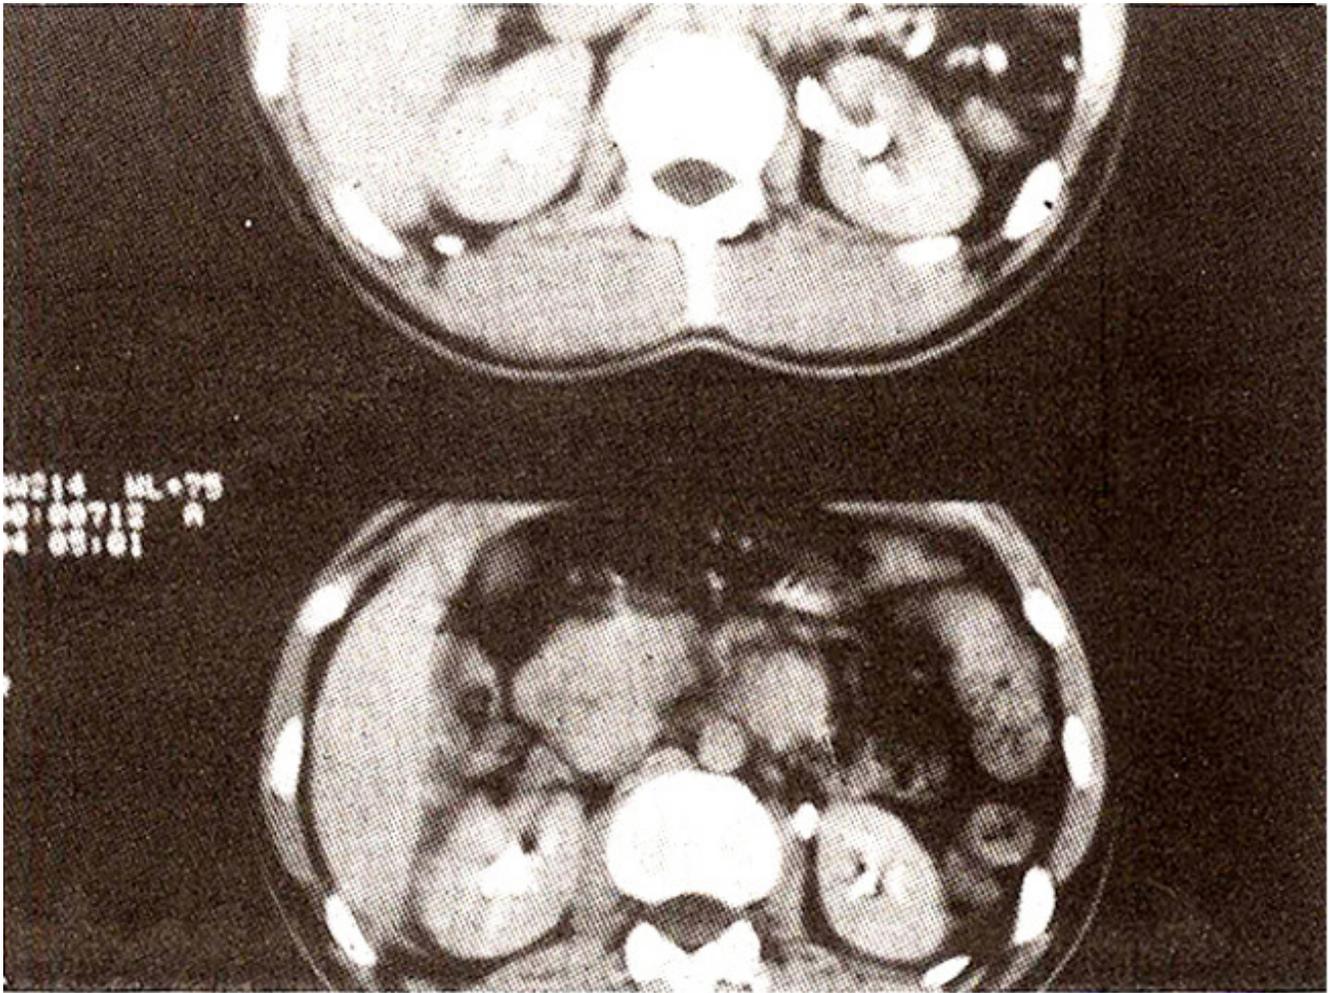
Follow -up CT Scan showing post-contrast enhanced axial section with complete resolution of the abscess.
